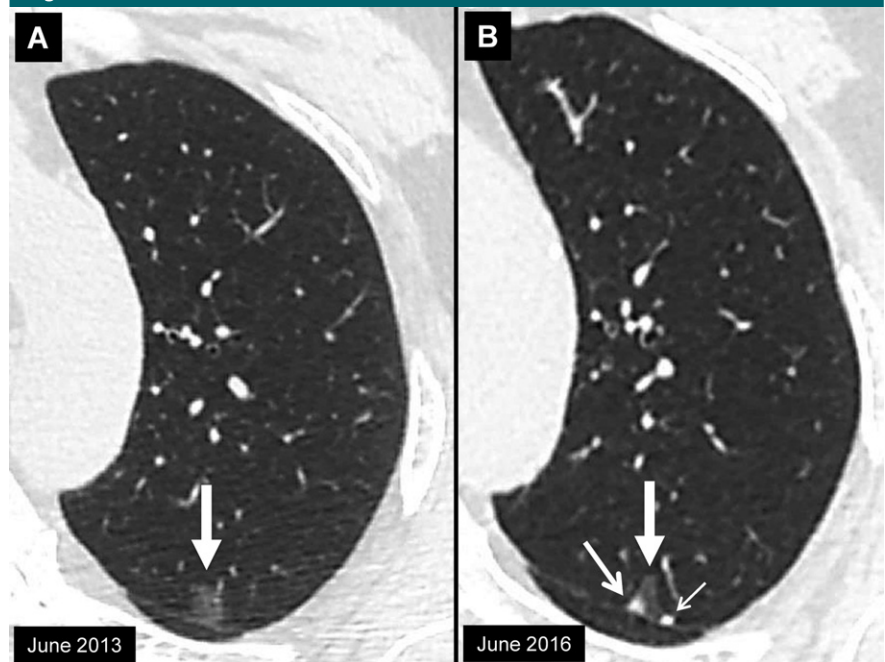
Transverse CT sections through a nodule (large arrow) in the left upper lobe at *A*, baseline and *B*, 3 years later. Over this time, the nodule has developed two solid components (small arrows). In part-solid nodules with multiple solid components, the maximum diameter of the largest solid component should be measured. In this nodule, only the larger component was measured (maximum diameter, 5 mm). The smaller solid component did not need to be measured.
